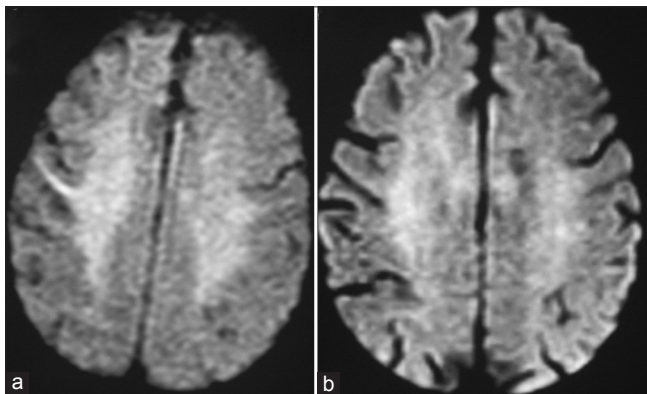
(a) High signal intensity was detected in right frontal cortex on diffusion-weighted MRI (b) The lesion had disappeared on MRI on the next day with the recovery from hypoglycemia
